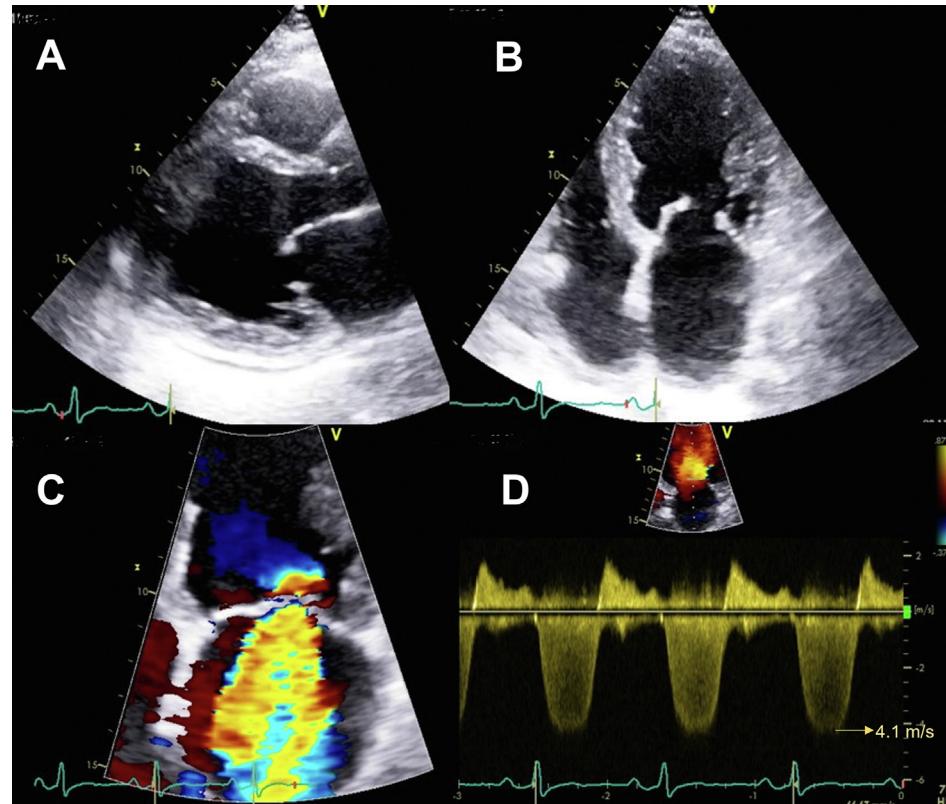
Pathological rheumatic mitral regurgitation. (A) Parasternal long-axis and (B) apical 4-chamber views showing thickened leaflets with doming typical of rheumatic MV in diastole. (C) Zoomed color Doppler image of pathological mitral regurgitant jet in systole, with a jet length ≥ 2 cm. (D) Continuous-wave Doppler waveform of transmитral flow showing pathological regurgitant flow with a peak velocity ≥ 3 m/s.
